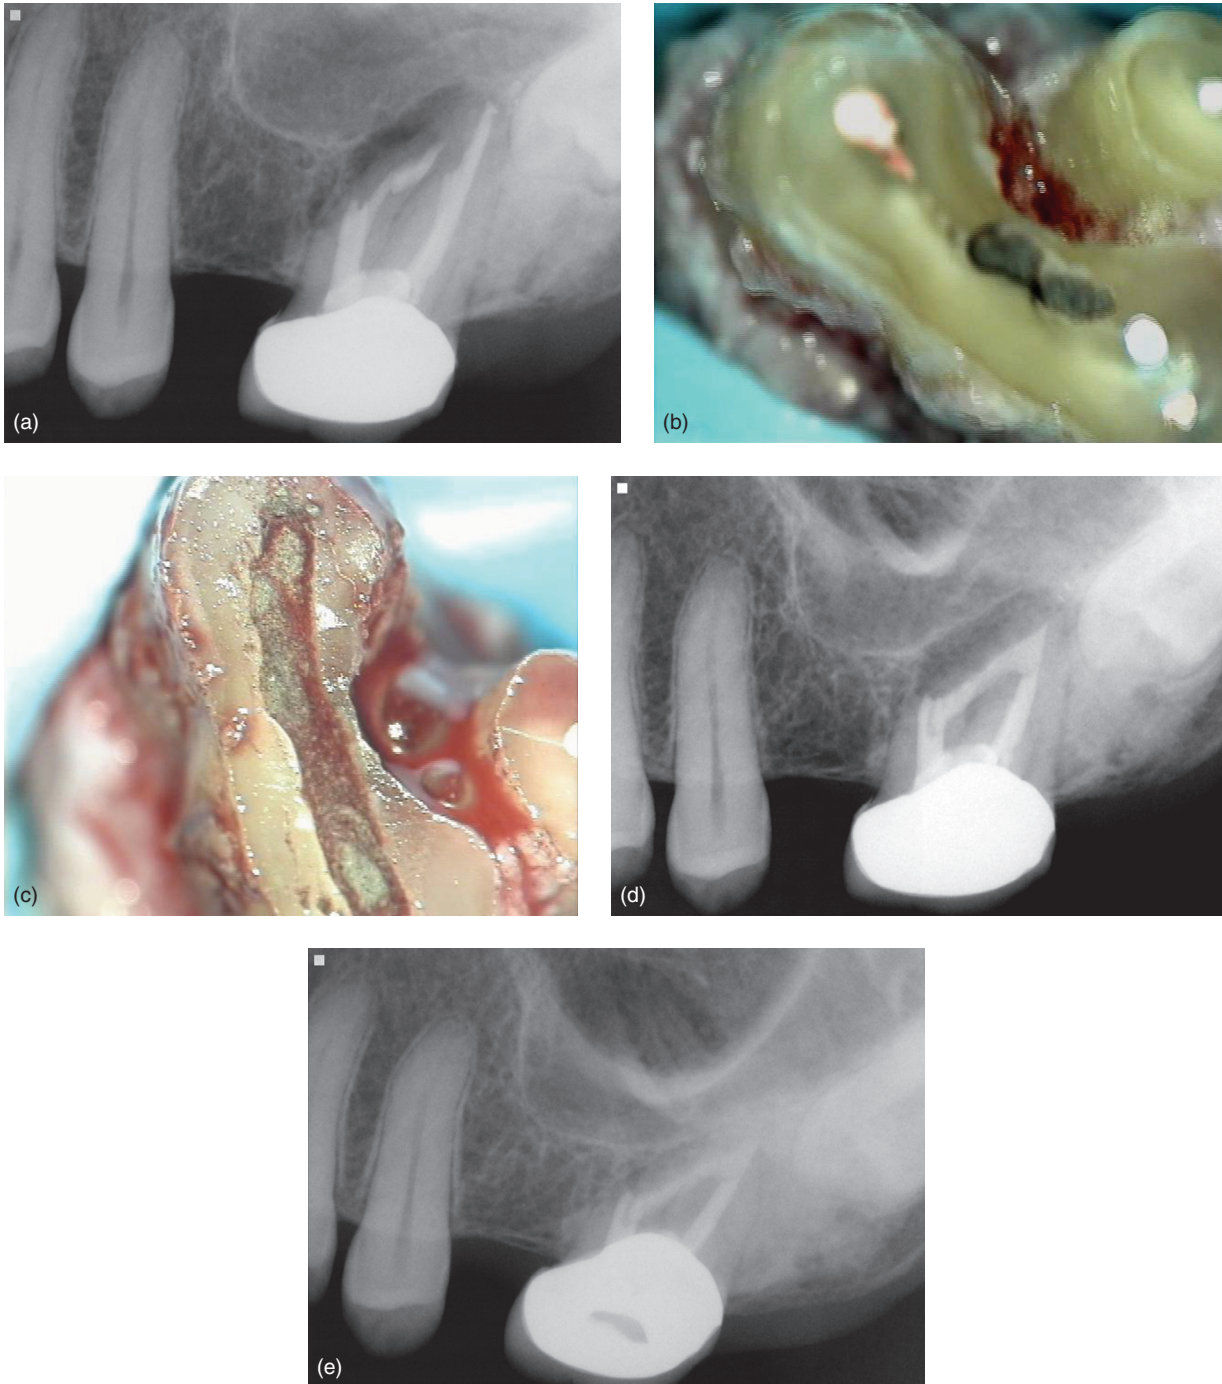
Maxillary left second molar with failed apicoectomy. Extraction/implant discussed with patient but patient wanted to try and save tooth. (a) Preop radiograph; (b) upon extraction, it was evident the previous apicoectomy identified an isthmus from MB toward palatal, but due to limitations, did not visualize that the isthmus extended all the way to include the palatal canal; (c) entire isthmus prepared (Bioceramic putty was used to fill the root end preparation); (d) postop radiograph; (e) one year recall with excellent healing.
